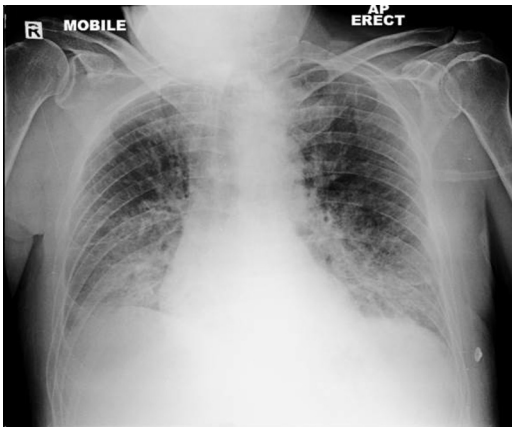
Chest X-ray showing mild bi-basal shadowing, but no evidence of bowel perforation.
